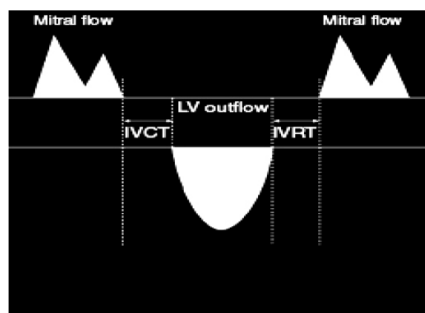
Measurement of Doppler interval from aortic valve (AV) opening to aortic valve (AV) closure.
